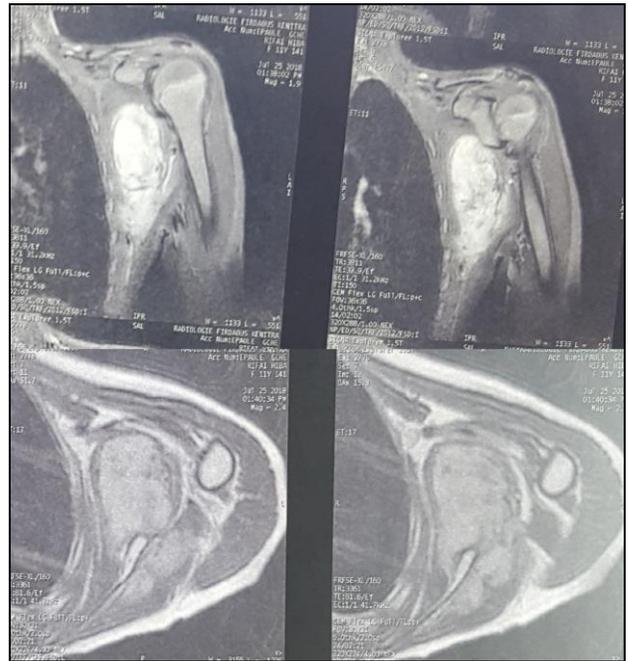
MRI of the left axillary region showing the tumoral process.
